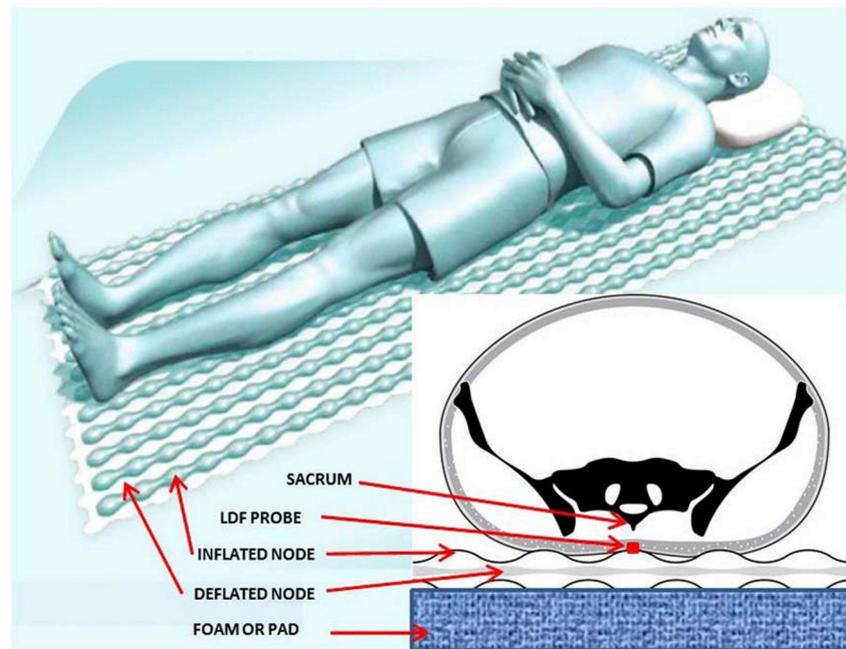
Alternating pressure surgical overlay placed over a foam operating room pad. The laser Doppler flow (LDF) probe was placed on the sacrum aligned with the apex of an overlay node (shown inflated in this figure).
